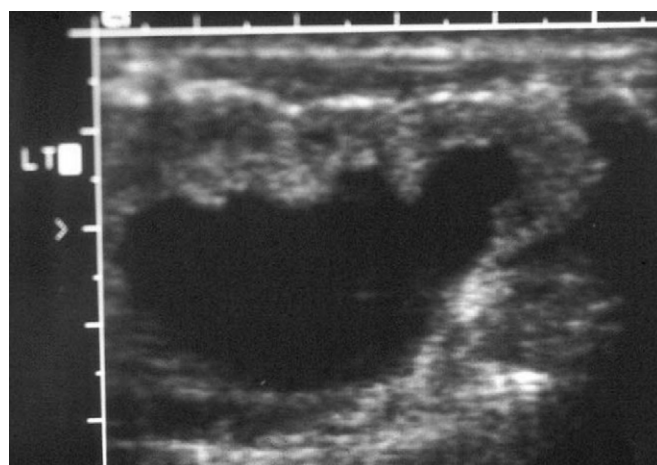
Sagittal ultrasonography of a kidney demonstrating hydronephrosis of the renal pelvis and calices. (Modified from Handel LN, Caldamone AA: Urinary tract infections in the pediatric population. *Lebanese Med J* 2004;52:194.)
